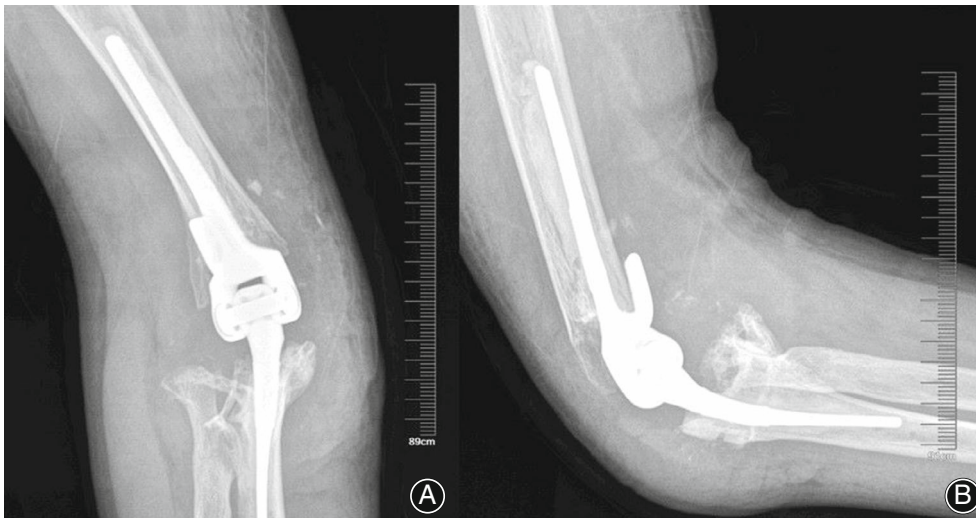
The X-ray of elbow joint of case 1 at 6 months after operation, showing the X-ray of the elbow joint of Case 1 at 6 months after operation (A: anteroposterior view; B: lateral view)
